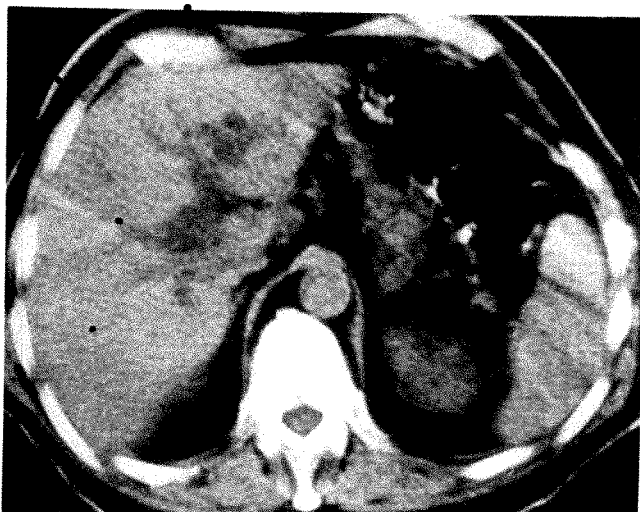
CT scan of 76-year-old man with jaundice showing dilated intrahepatic bile ducts as linear branching structures of low density radiating from porta hepatis. Mass within pancreatic head seen on lower level cuts. Surgery disclosed obstructing carcinoma of head of pancreas.
